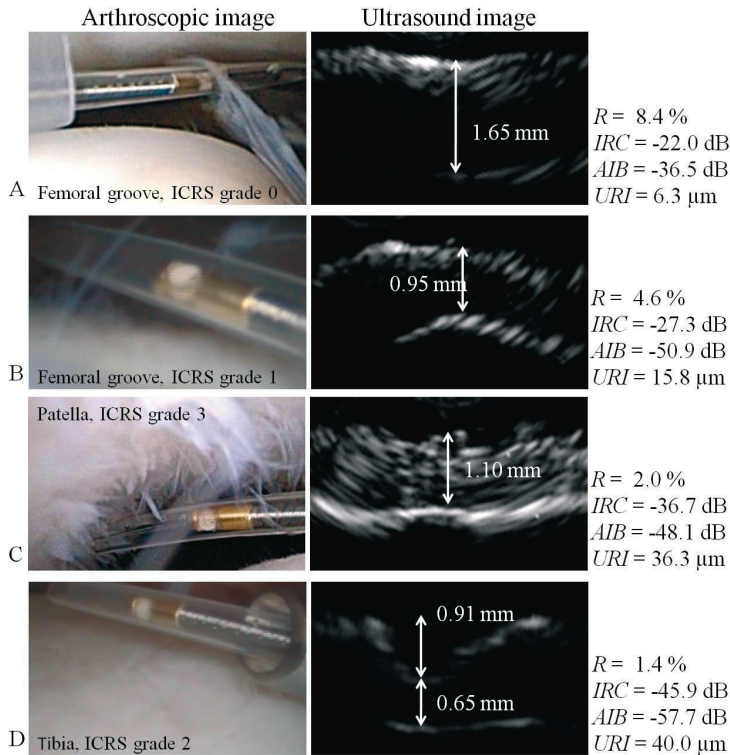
Arthroscopic and ultrasound images of articular cartilage in the human knee joints. The diameter of the ultrasound catheter (visible in the arthroscopic images) is 1 mm. The International Cartilage Repair Society (ICRS) grade assessed for each measurement site is shown on the arthroscopic images. In the ultrasound images, the direction of the incident ultrasonic signal is from the physiological saline (above) to the articular cartilage (below). The quantitative ultrasound parameters calculated using the ultrasonic signal are shown on the ultrasound images.
